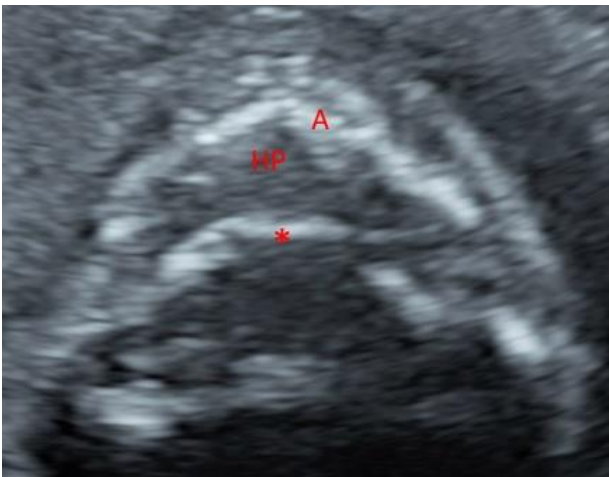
Palate view with 2D ultrasound: A, alveolar bone; HP, hard palate; *, soft hard palate interface
